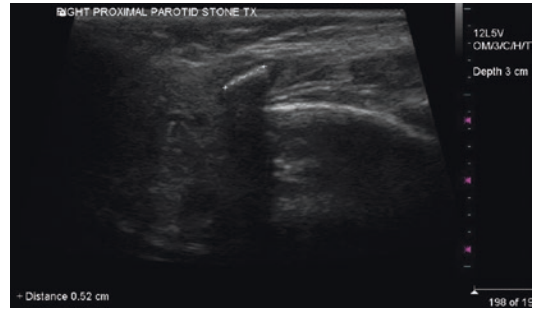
Ultrasound image of right proximal parotid stone (5.2 mm); stone casts a typical distal acoustic shadowing
